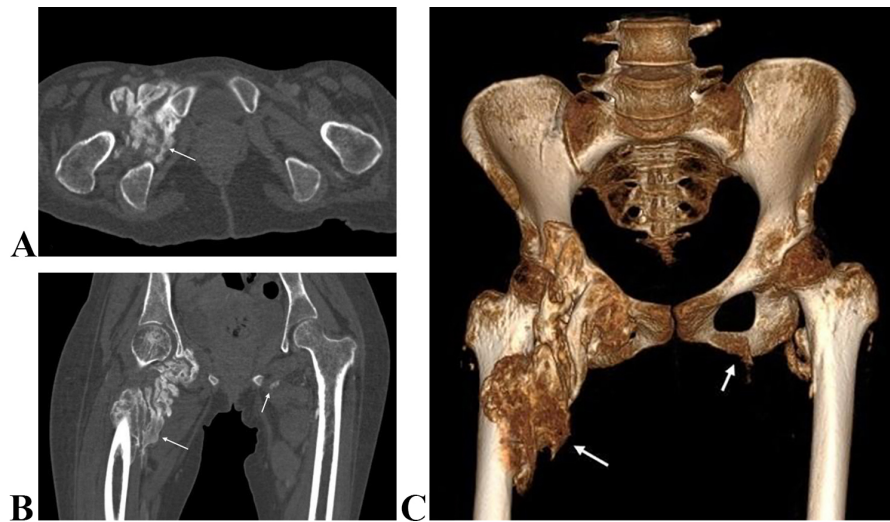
CT scan of the pelvis in axial section (A), coronal reconstruction (B), and volume rendering (C): multiple intramuscular calcifications of pericoxofemoral location, more marked on the right.
